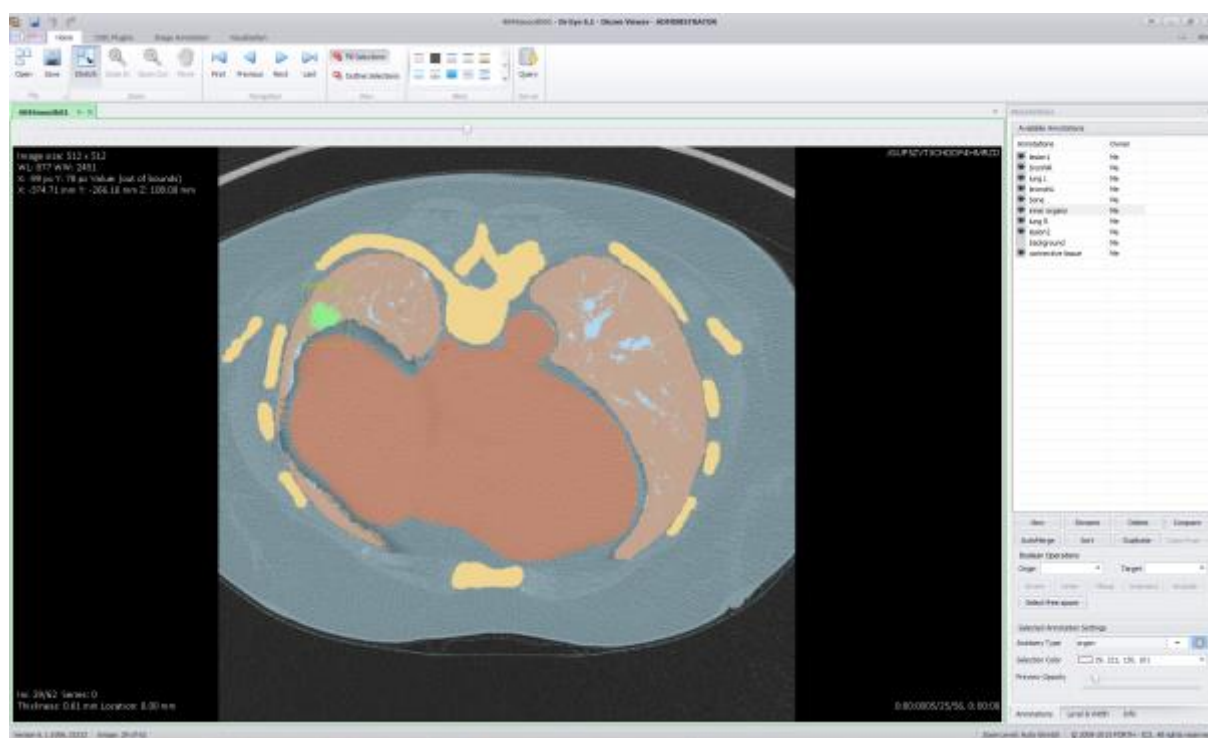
The main window of the DrEye platform with an MRI data set and annotations
